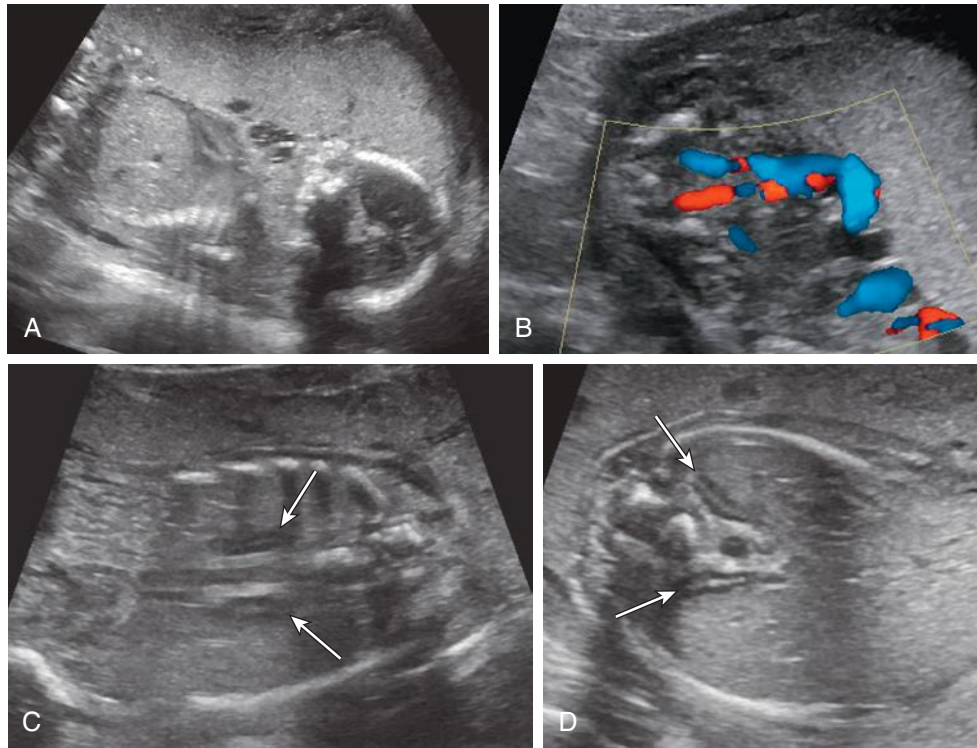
Bilateral renal agenesis. A, Anhydramnios. B, Empty bladder, demonstrated using color Doppler sonography. Coronal (C) and axial (D) images through the fetal abdomen demonstrating elongation owing to absence of the kidneys bilaterally, the so-called “lying down adrenal” sign.
